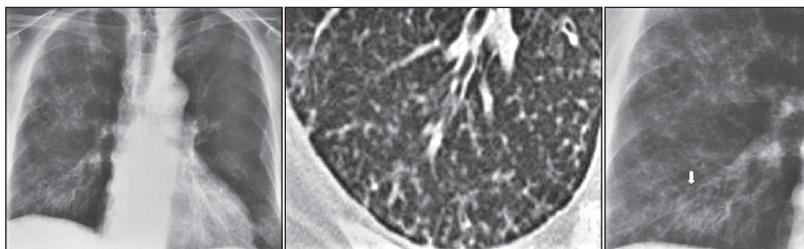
Chest X-ray of a 30 year old immunodeficiency virus positive male. Note in the left the peribronchovascular thickening. In the right hand film is a blown up image showing the peribronchovascular thickening more clearly (watch the arrow). The high resolution computed tomography (in the middle) render bronchiectasis, centrilobular nodularity (tree-in-bud) and mosaic attenuation in the same patient.
